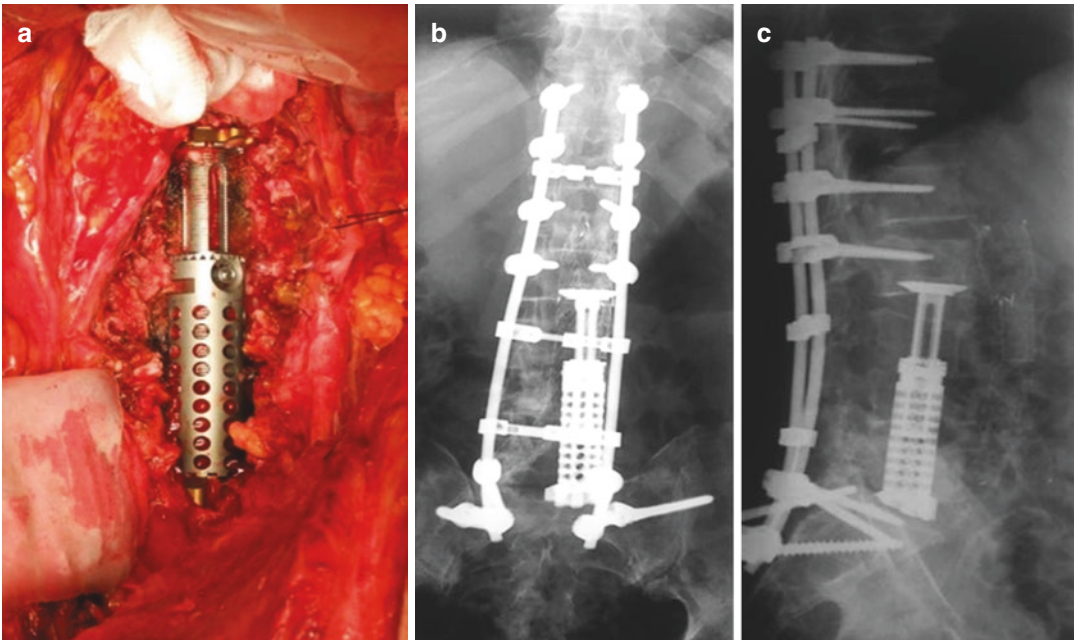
(a) Intraoperative pictures depicting placement of expandable mesh cage. (b, c) 12-month postoperative AP and lateral X-rays showing slight settling of mesh
